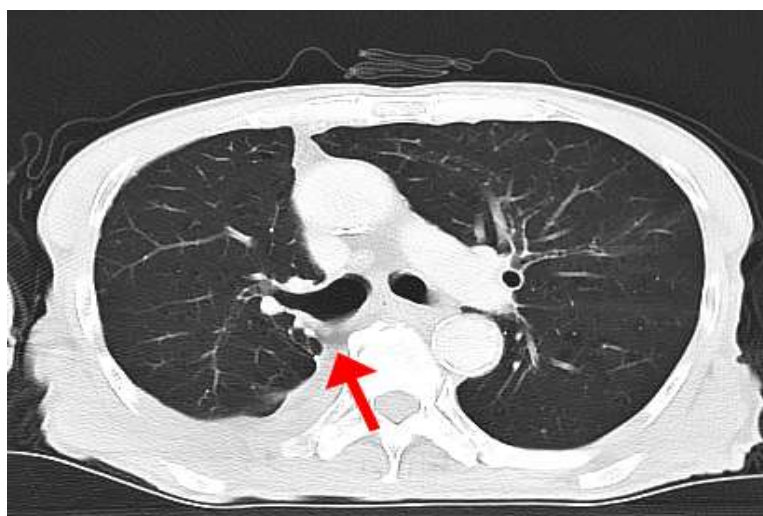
Axial chest computed tomography image 2 year later reveals that the cavity disappeared and the free pericardial fat pad remained in place (red arrow).
